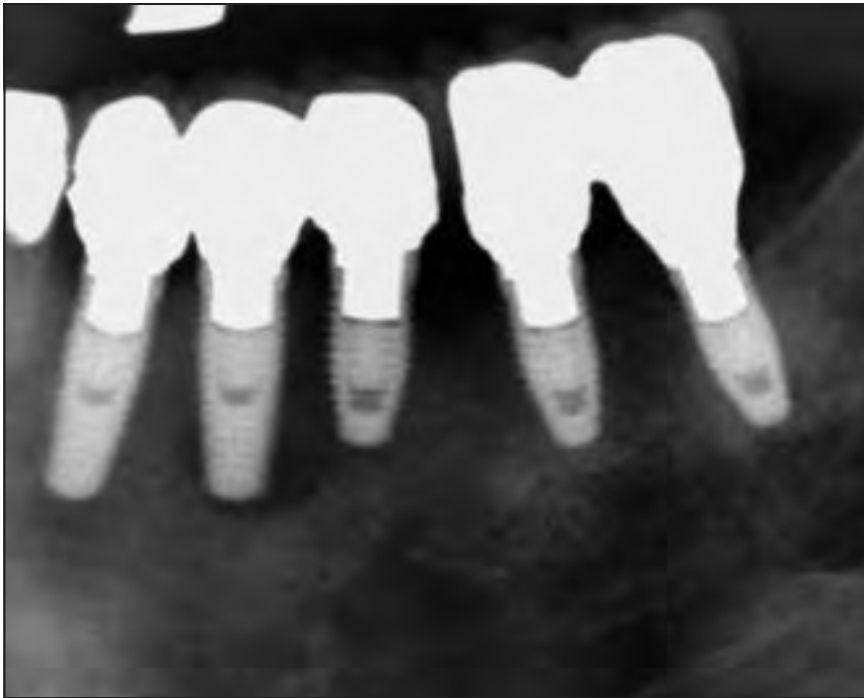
Radiograph showing considerable bone loss around the implants in the mandibular left posterior quadrant.
